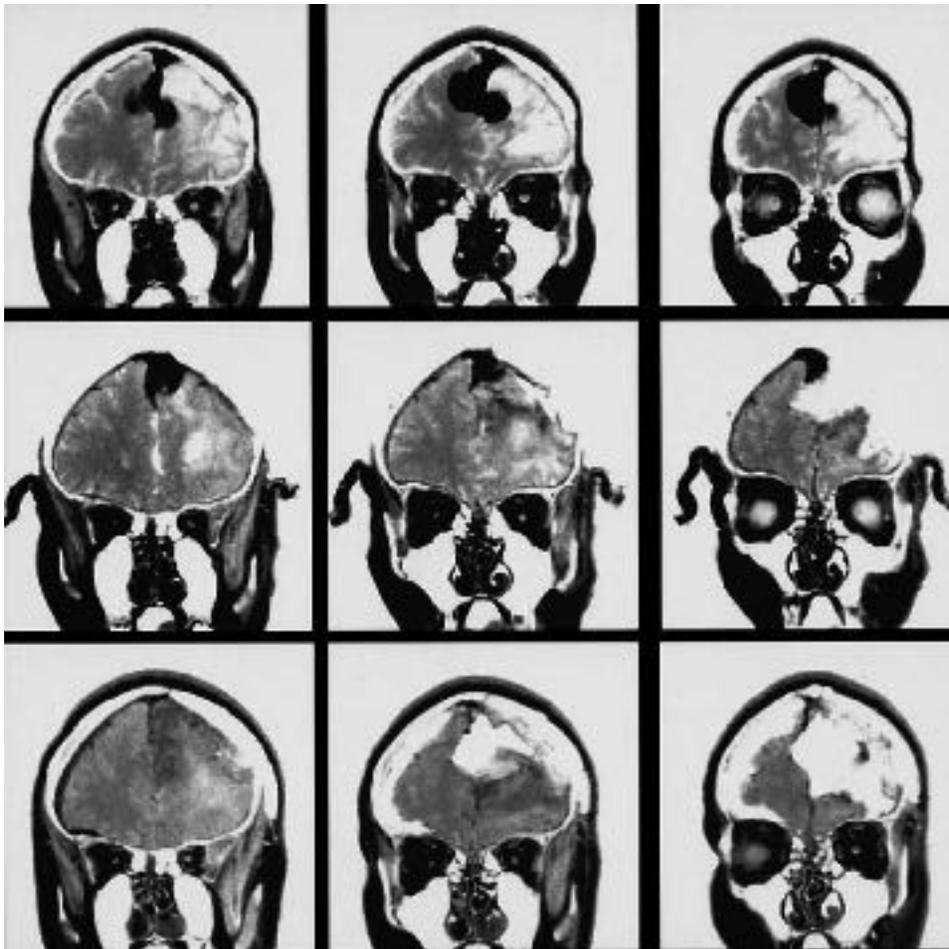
Previously published T1-Gd images obtained from a patient with recurrent anterior parafalcine meningioma. These images were acquired in 1998, using the prototype 1.5T intraoperative magnetic resonance imaging system. (Upper panel) Surgical planning images showing the parafalcine meningioma. (Middle panel) Intradissection images acquired following presumed total resection of the tumor, demonstrating unsuspected residual neoplasm. (Lower panel) Quality assurance images acquired following wound closure, but before reversal of anesthesia. Used with permission of Kaibara T, Saunders JK, Sutherland GR. Utility of a moveable 1.5 tesla intraoperative MR imaging system. *Can J Neurol Sci* 1999;26,4:315.
